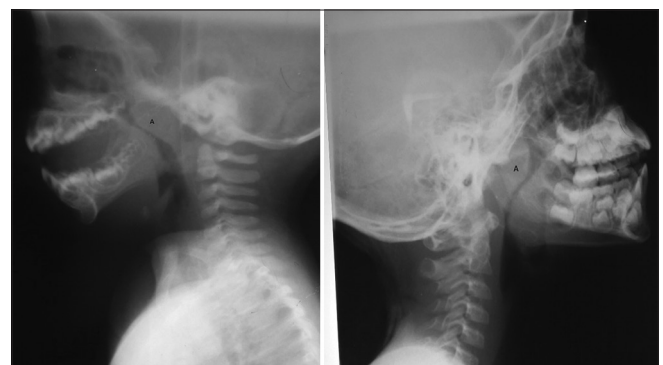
Post-nasal space radiographs showing enlarged adenoids (A) with nasopharyngeal airway obstruction
